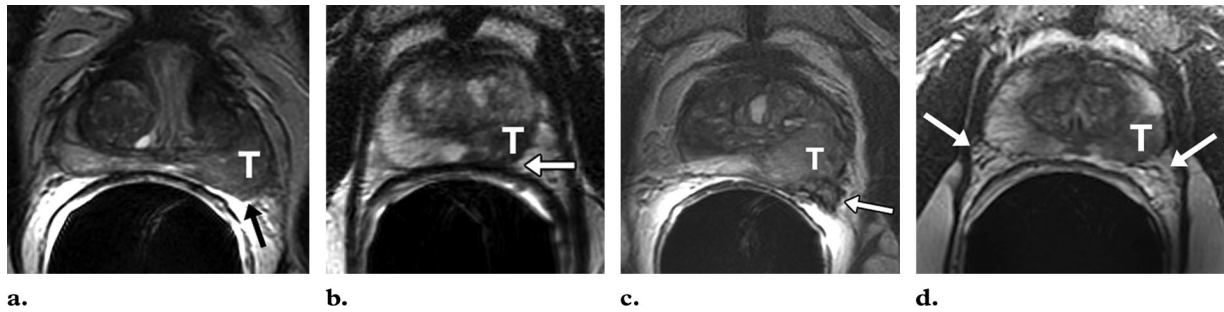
Four different prostate cancer cases with extracapsular extension of the tumor (*T*). T2-weighted axial MR images show an asymmetric bulge and spiculated margin (arrow in a), obliteration of the rectoprostatic angle (arrow in b), breach of the capsule with direct tumor extension and envelopment of the neurovascular bundle (arrow in c), and asymmetry of the neurovascular bundles (arrows in d).
